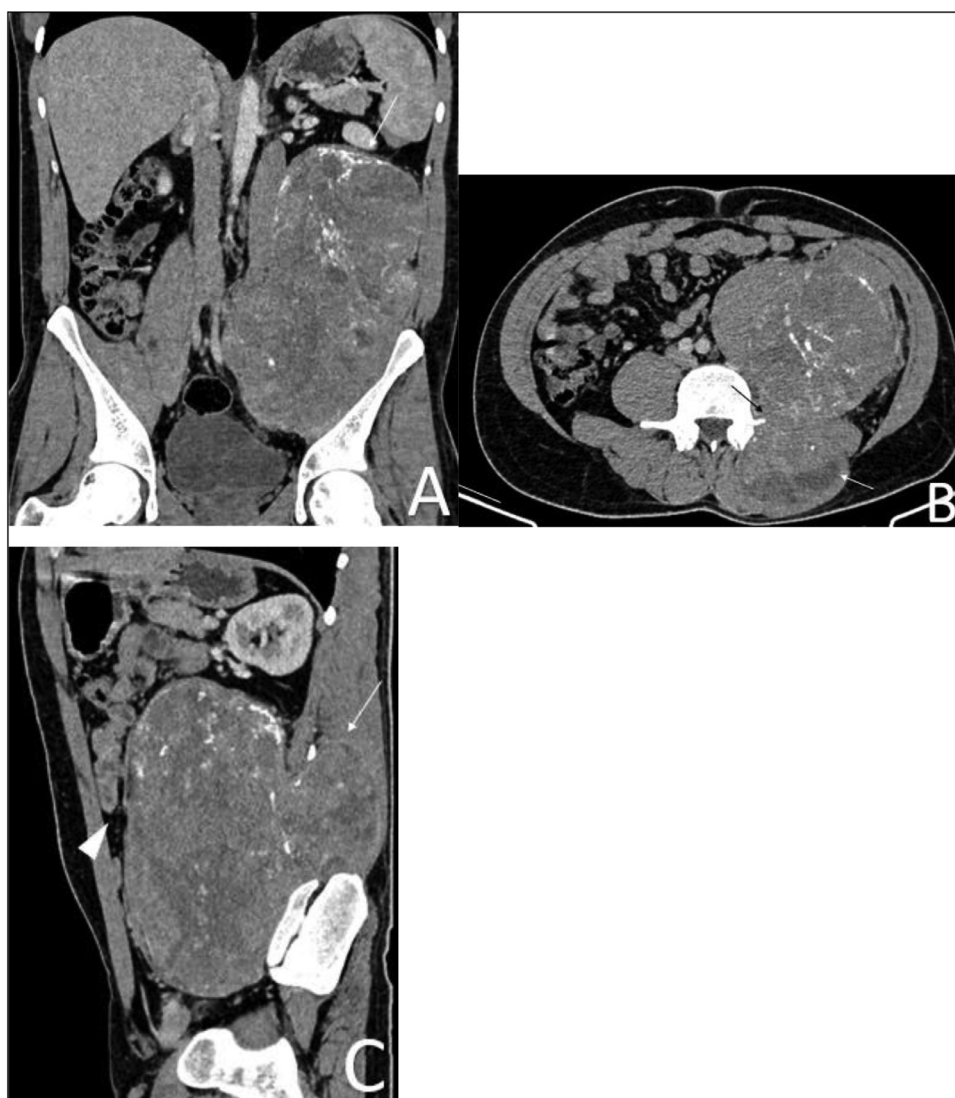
CT scan images: (A) The coronal plane shows a large heterogenous mass extending from L2 to S4, with numerous calcifications attached to the upper edge of the mass (white arrow). (B) The axial plane shows invasion of iliocostalis lumborum and longissimus thoracis muscles (white arrow); Lysis of the left transverse process of L4 is also visible (black arrow). (C) The sagittal plane shows invasion of the back muscles (white arrow), with the bowels pushed forward (white arrow head).
